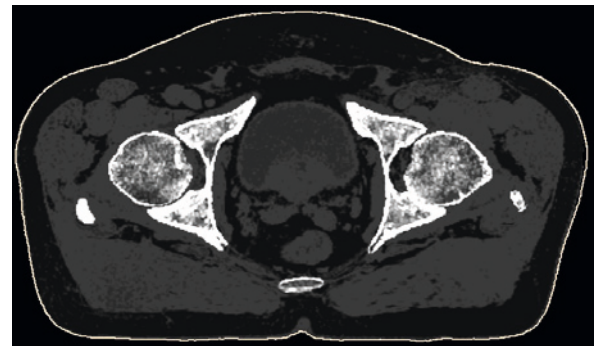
A constructed MRI-based pseudo-CT image of a prostate cancer patient.
